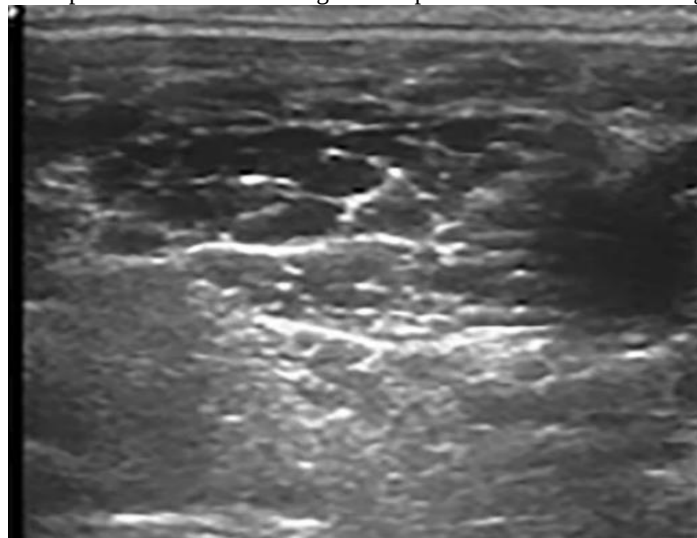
The Ultrasound appearance of the lesion
